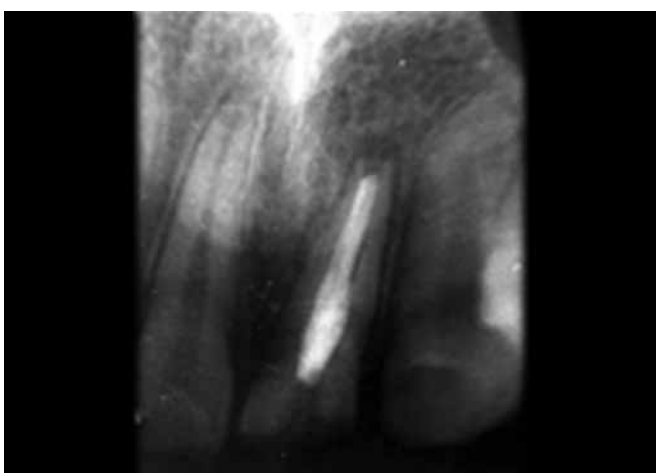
Preoperative radiograph (case 2)
